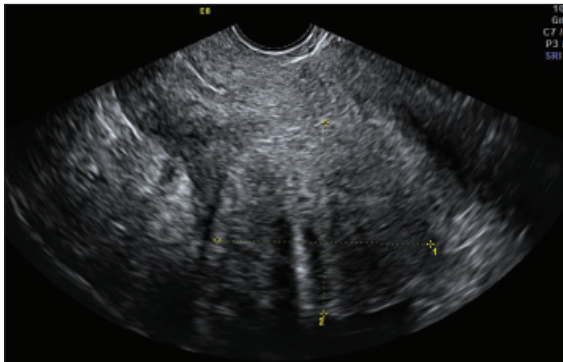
Uterine fibroids at ultrasound
